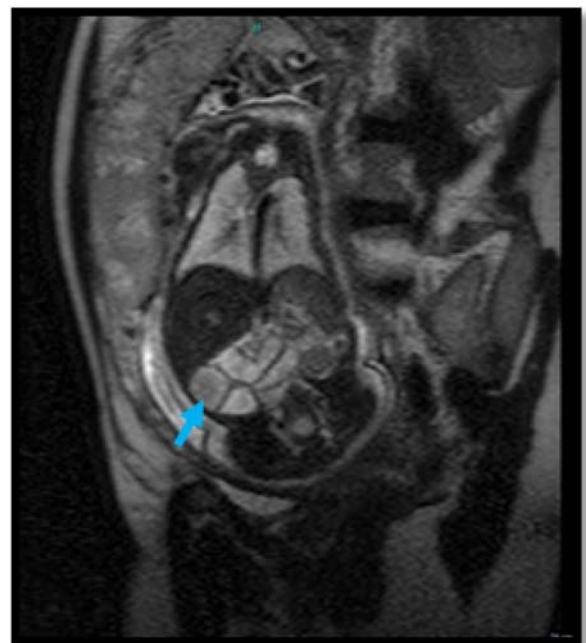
MRI showing – dilatation of jejunum.
